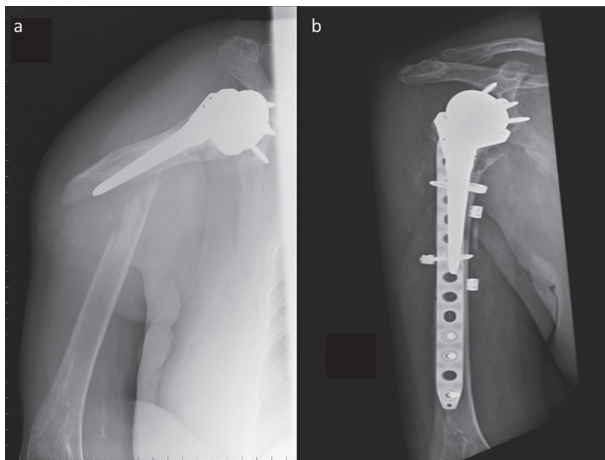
A 78-year-old woman, right-handed, fell to the ground 10 years after cemented RTSA implantation for right shoulder cuff tear arthropathy. a) pre-op radiograph showing periprosthetic humeral fracture. b) post-operative radiograph showing fracture reduction and fixation with 4.5mm 14 holes locking plate with cerclages and screws. Clinical healing with full activities of daily living recovery was documented at 18 months
